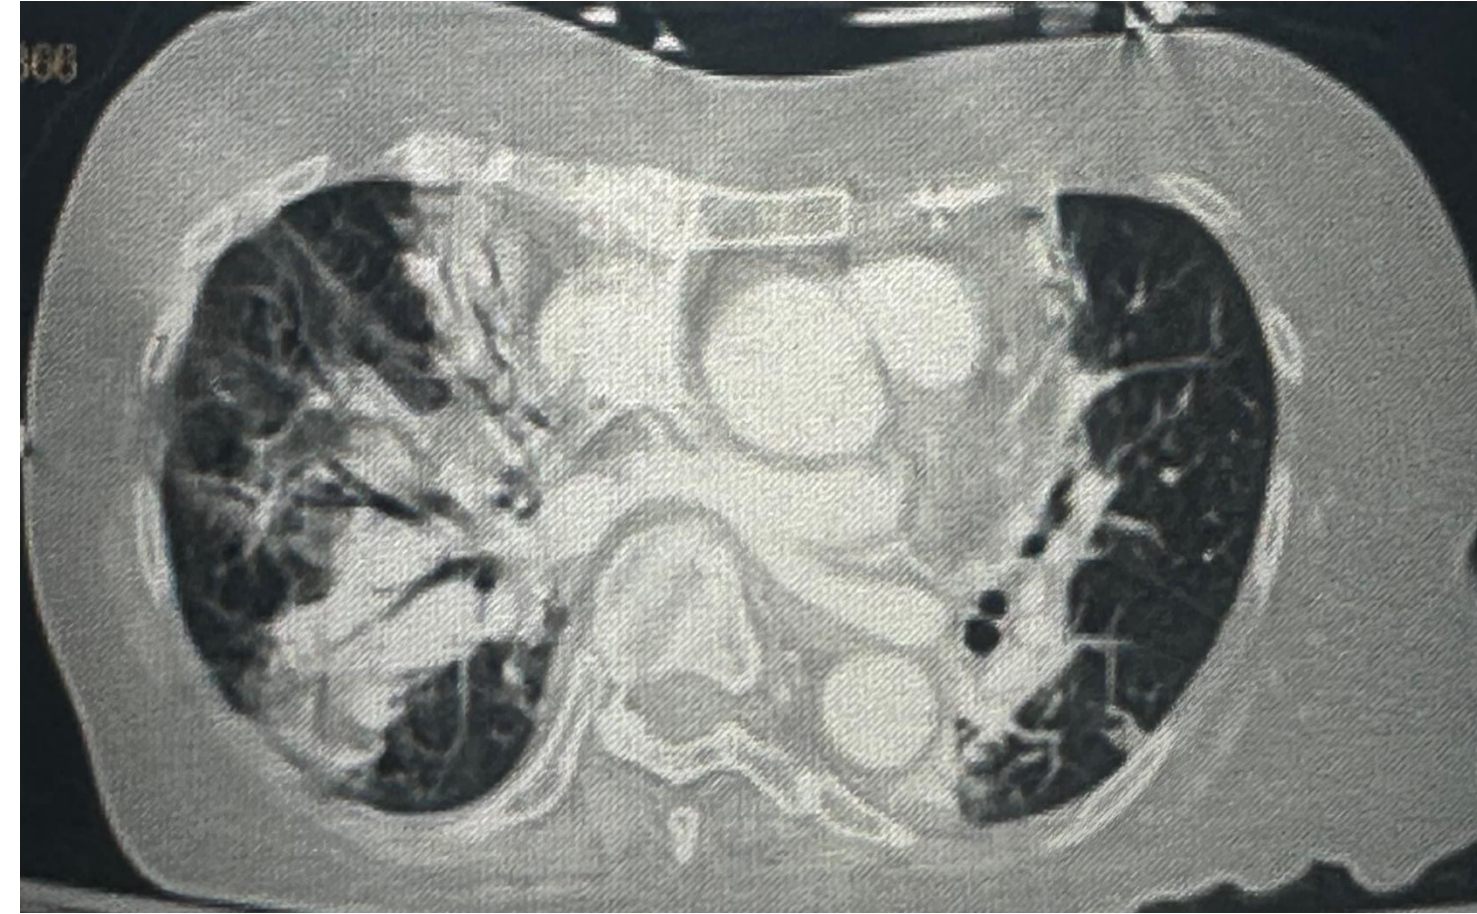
CTA of the chest showing mild enlarged pulmonary trunk measuring 3.2cm. Patchy airspace opacities in the right upper, right lower, and left lower lobes presenting multi-lobar pneumonia.
